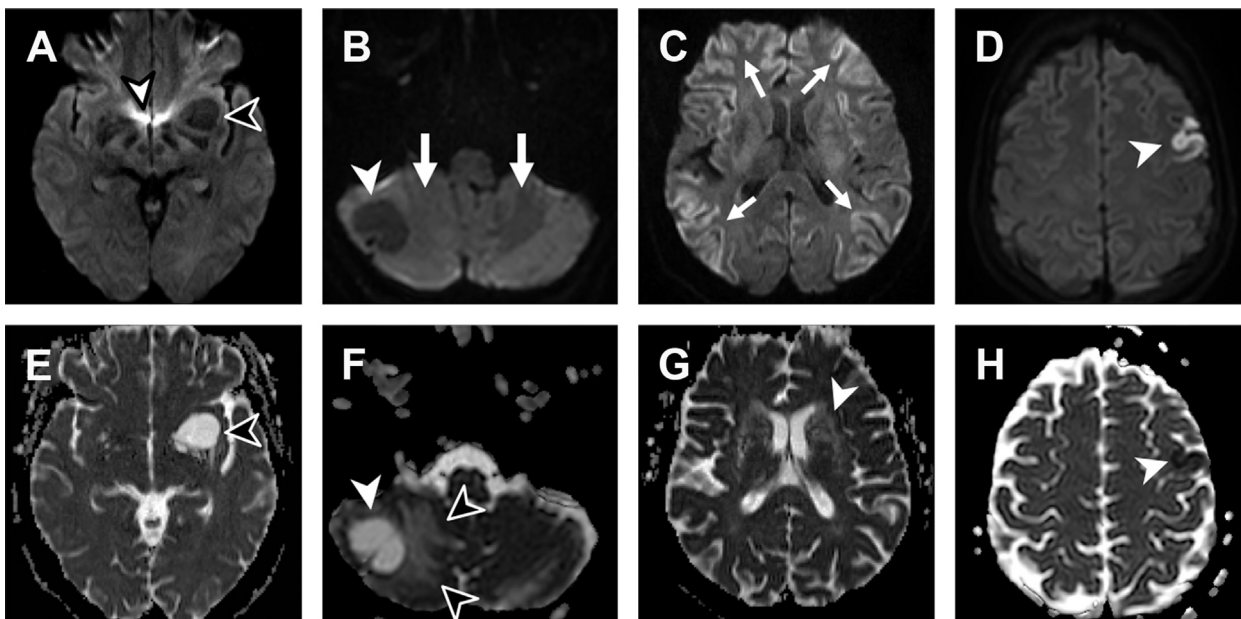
DWI b1000 (top row) and corresponding ADC images (bottom row) from 4 cases. (A–E) Giant Virchow-Robin space in the area of the left basal ganglia (*black arrowhead*). The signal of the abnormality follows CSF on every sequence. Susceptibility artifact is creating high signal and distortion on DWI (*white arrowhead*). (B–F) Cystic tumor in the right cerebellar hemisphere (*white arrowheads*). Its appearance is similar to that of the enlarged perivascular space in (A–E); however, there is vasogenic edema in the parenchyma, which is prominent on ADC (F, *black arrowheads*). On DWI the edema appears as only a mild increase of white matter signal compared with the normal left side (B, *white arrows*) owing to T2 shine-through. (C–G) Diffuse cortical diffusion restriction is seen on the DWI image in both frontal lobes, parietal lobes, and insula, typical for Creutzfeldt-Jakob disease (*arrows*). ADC is less demonstrative of these findings. In the basal ganglia increased diffusion is seen on ADC, owing to the high number of enlarged perivascular space (L'etat crible, *white arrowhead* in G). (D and H) An acute cortical infarct with diffusion restriction as demonstrated by the high DWI signal and corresponding marked ADC hypointensity.
